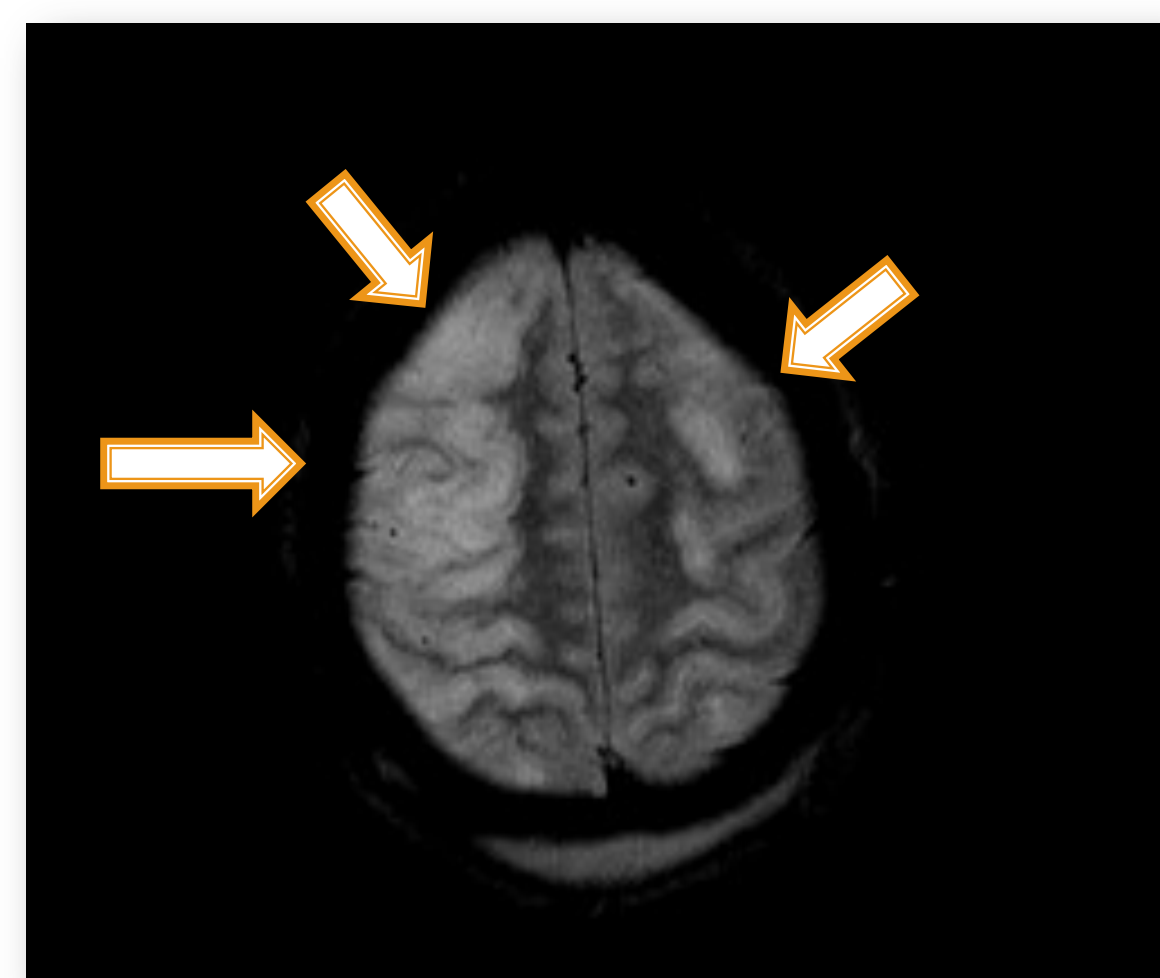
Flair image showing cortical ribboning in the right greater than left frontal lobes which corresponded to restricted diffusion seen on the DWI image. This abnormal signal represents completed infarction in the right greater than left frontal lobes.
